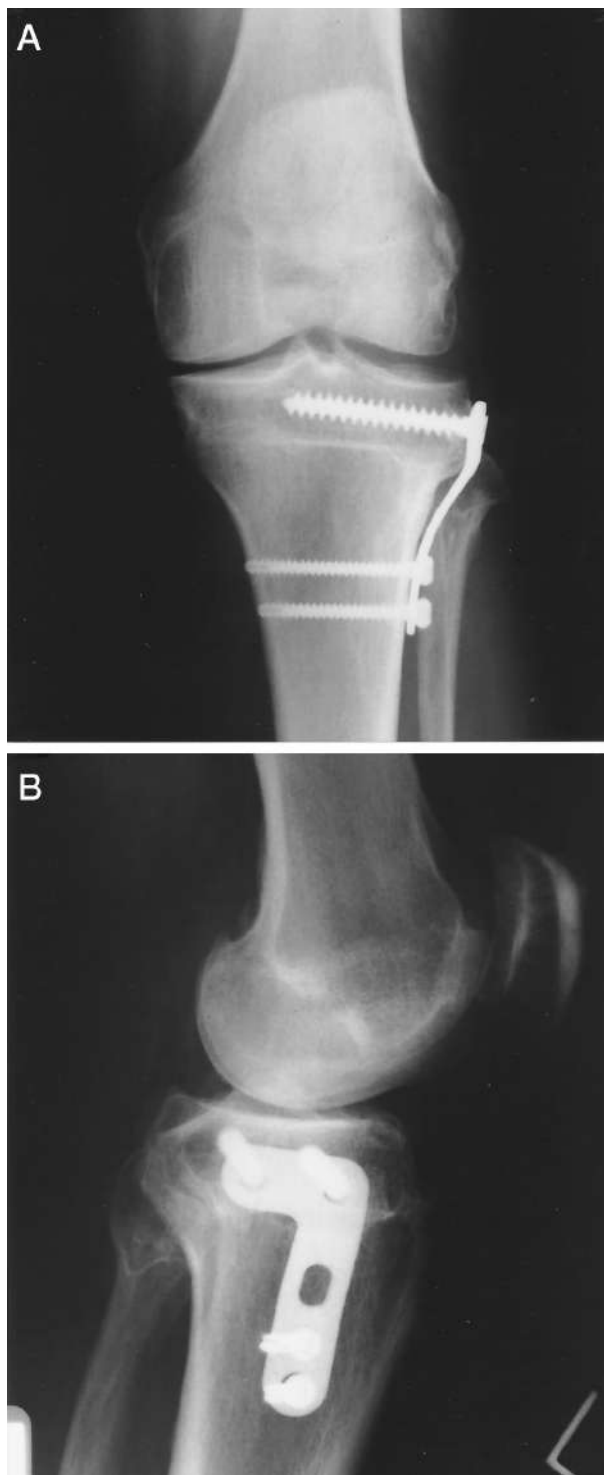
Anteroposterior (A) and lateral (B) radiographs show the postoperative appearance after proximal tibial osteotomy, fibular osteotomy, and internal fixation.
